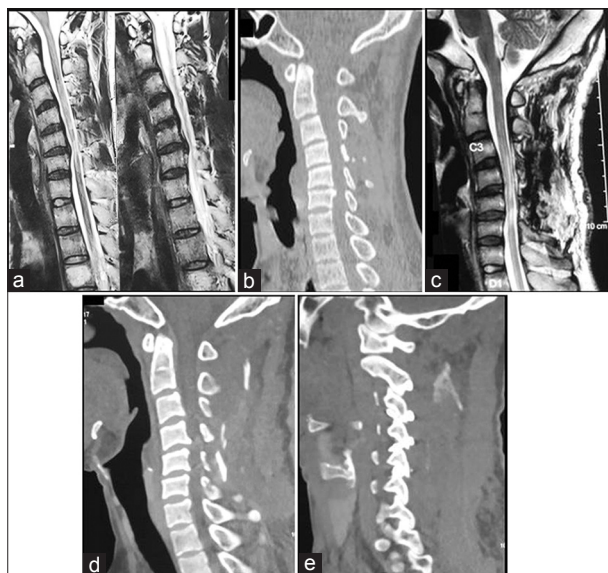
Images of a 24-year old male patient. (a) Sagittal T2-weighted image showing the disc prolapsed at C5-6 level. (b) Preoperative computed tomography scan. (c) Postoperative magnetic resonance imaging performed 24 h after surgery showing the restoration of the prolapsed disc with relief of cord compression. (d) Postoperative sagittal computed tomography scan showing the increase in the disc space height. (e) Sagittal computed tomography scan with the cut passing through the facets showing the C2-3, C3-4, C4-5, and C5-6 transarticular fixation with C3-4, C4-5, and C5-6 facetal spacer
